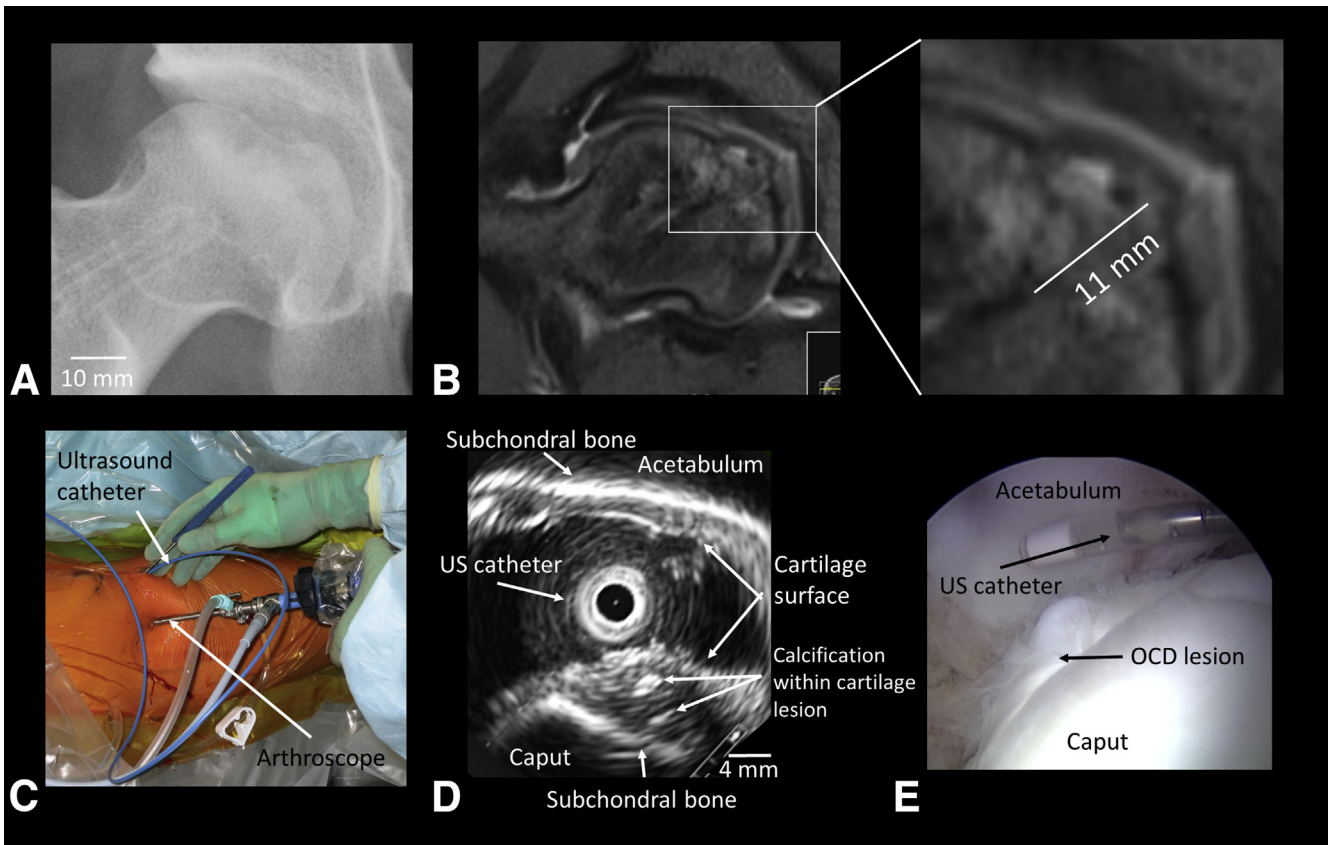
(A) Plain radiographic image of right proximal femur (posterior-anterior direction). (B) Magnetic resonance image of right proximal femur (proton density, coronal plane) with site of osteochondritis dissecans (OCD) lesion magnified. (C) Anterior and anterolateral arthroscopic portals used to conduct ultrasound arthroscopy. (D) Representative ultrasound image of OCD lesion in coronal plane (ultrasound [US] catheter in anterior portal). (E) Arthroscopic view of OCD lesion (arthroscope in anterolateral portal). Ultrasound (US) imaging provided highly detailed information on the OCD lesion. The real-time evaluation of the extent of the lesion, as well as the assessment of the cartilage inner structures and subchondral bone, was possible.
